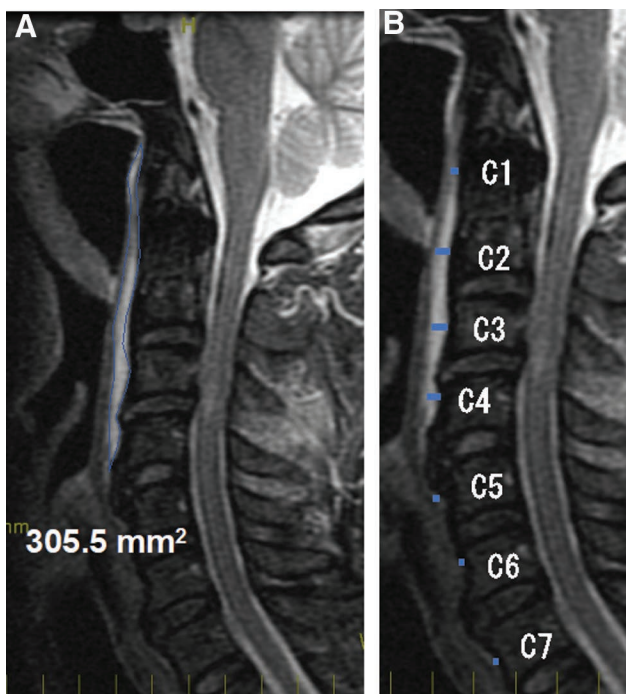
The prevalence of the prevertebral high-intensity area (A) and high-intensity anteroposterior width (B) at C1–C7 vertebral level was evaluated by short T1 inversion recovery midsagittal magnetic resonance images.
